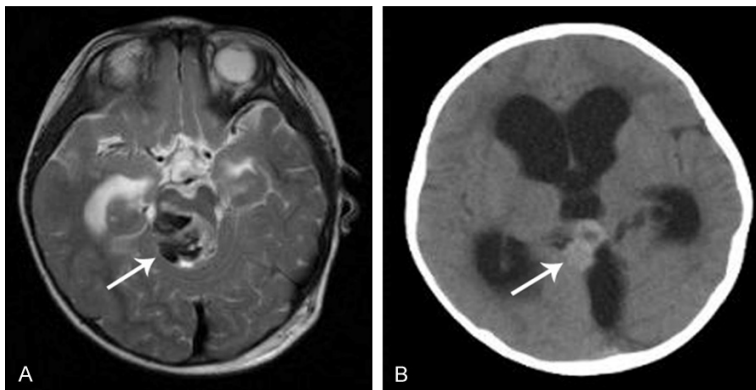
A: T2-weighted image showed intratumoral-hemorrhage-like signal. B: Postoperative CT scan revealed tumor recurrence after 3 months in 2 years old patient.
